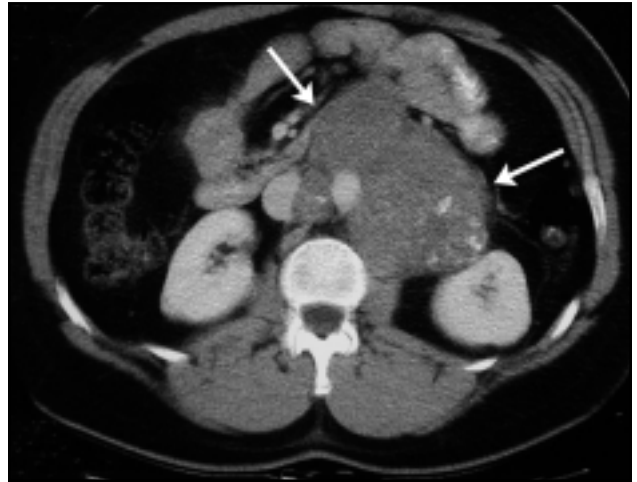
CT scan showing residual retroperitoneal tumor after chemotherapy at the level of the lower pole of the kidneys.
